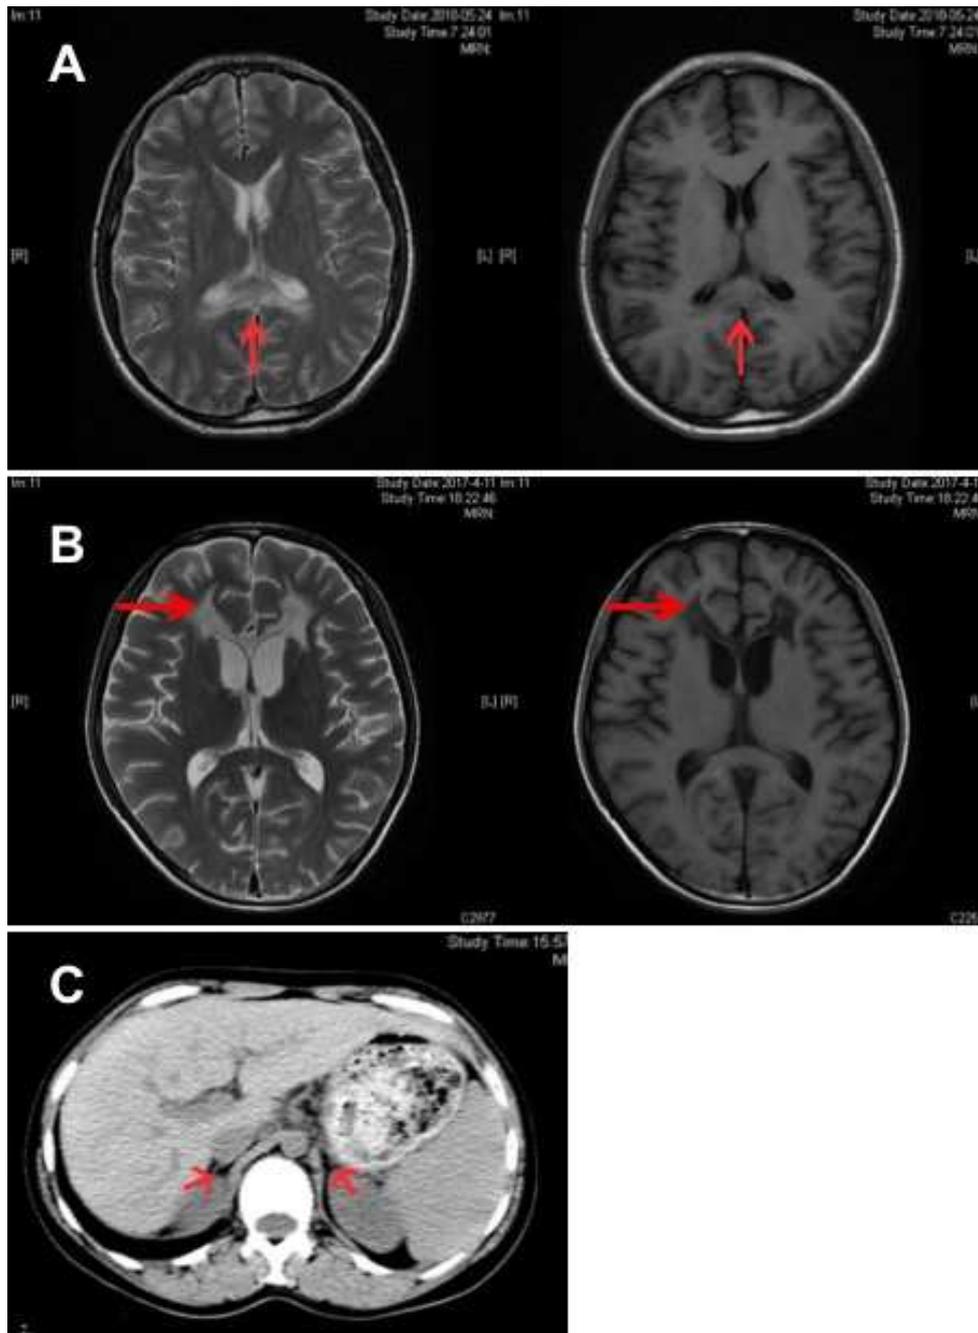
Brain magnetic resonance imaging (MRI) scan of patients. A.
